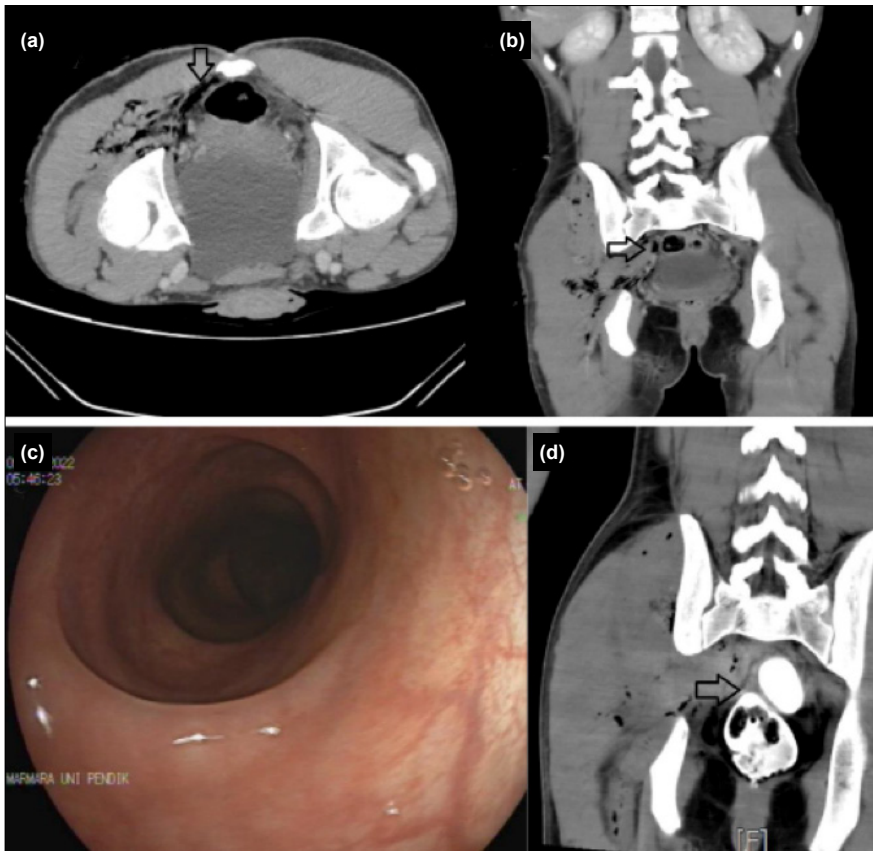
(a) Bullet trajectory and air bubbles in the right pararectal area. (b) Bullet trajectory extending from the right gluteal region to the pararectal area. (c) Same-day rectosigmoidoscopy showing intact mucosa. (d) Pre-discharge rectal contrast-enhanced computed tomography (CT) showing no contrast leakage.
